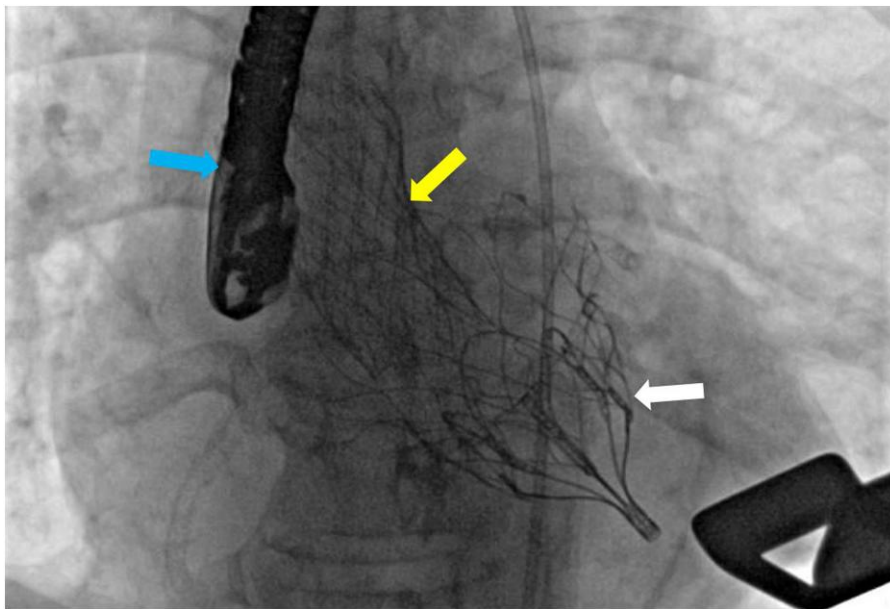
Cardiac catheterization still image showing the Tendyne valve (white arrow), transcatheter aortic valve implant (yellow arrow), and transoesophageal echocardiography probe (blue arrow).
